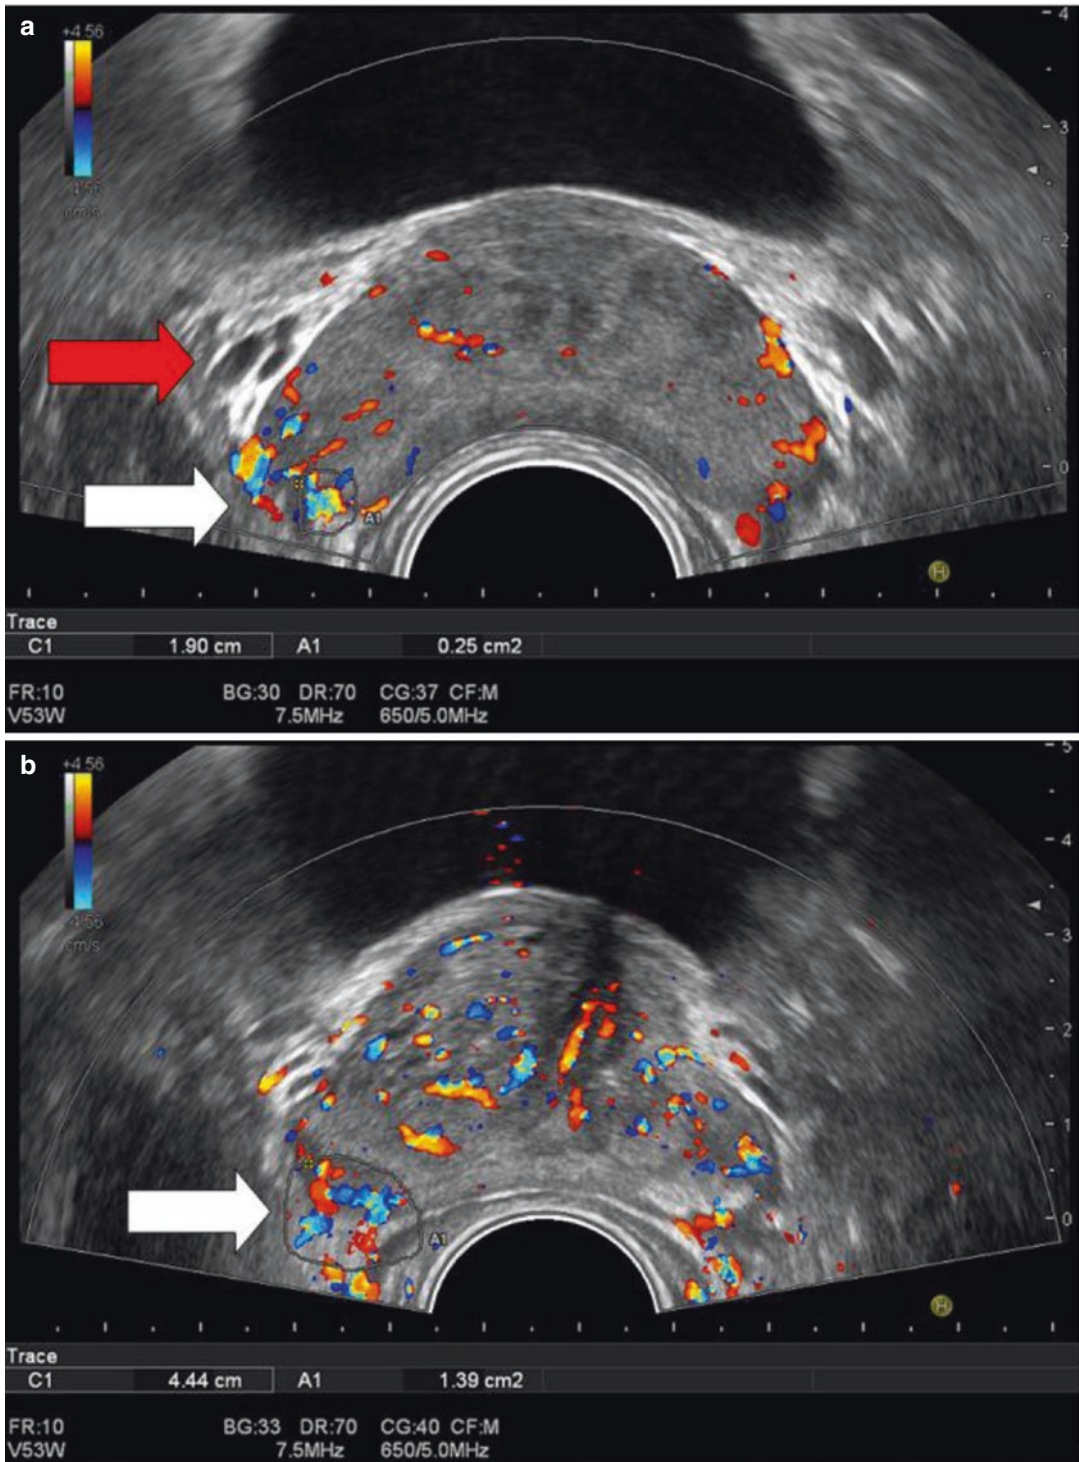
(a) The neurovascular bundle is visible in the transversal scan in posterolateral region of the prostate, also with the help of color Doppler (*white arrow*). The shape can be roundish or triangular, and it is constituted by
